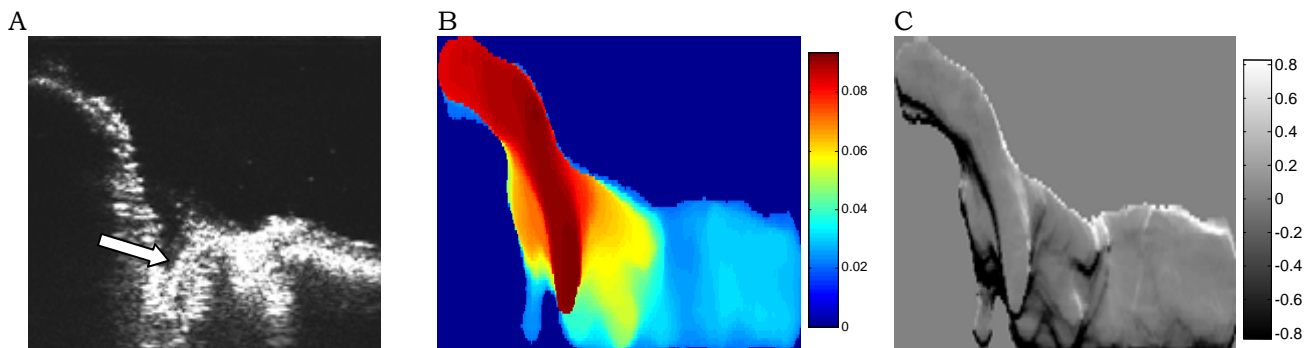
A) A sonogram of the femur (left), the tibia (right) and the ACL-bone insertion (arrow); B) Displacement image (mm) and C) elastogram (%) during stretching of the ACL. Note the 'ridge' formed at the insertion.
